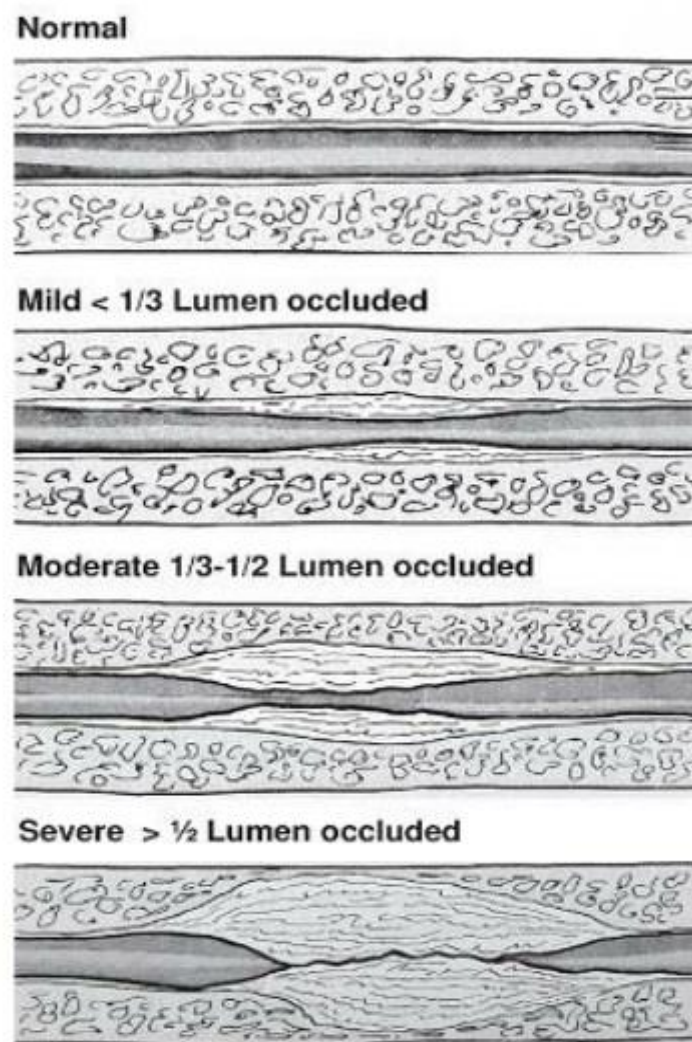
Ultrasound classification of the degree of urethral occlusion (25).
